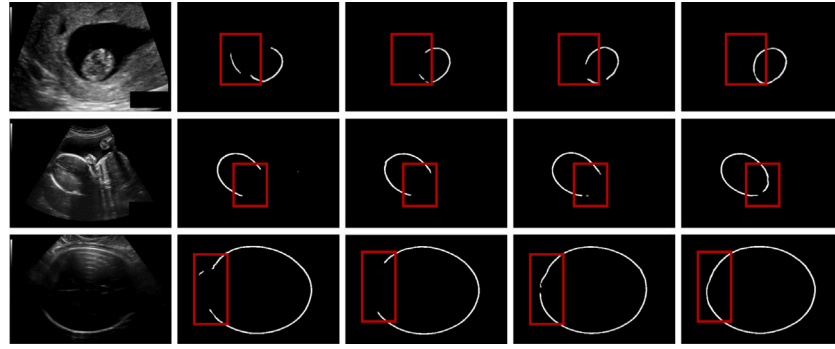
Qualitative evaluation of ablation study on the HC-18 test set. From top to bottom, there are examples in the first trimester, second trimester, and third trimester, respectively. From left to right, each column shows the original ultrasound images (first column), and the boundary detection results obtained by Model 1 (second column), Model 2 (third column), Model 3 (fourth column), and Model 4 (fifth column), respectively. .
